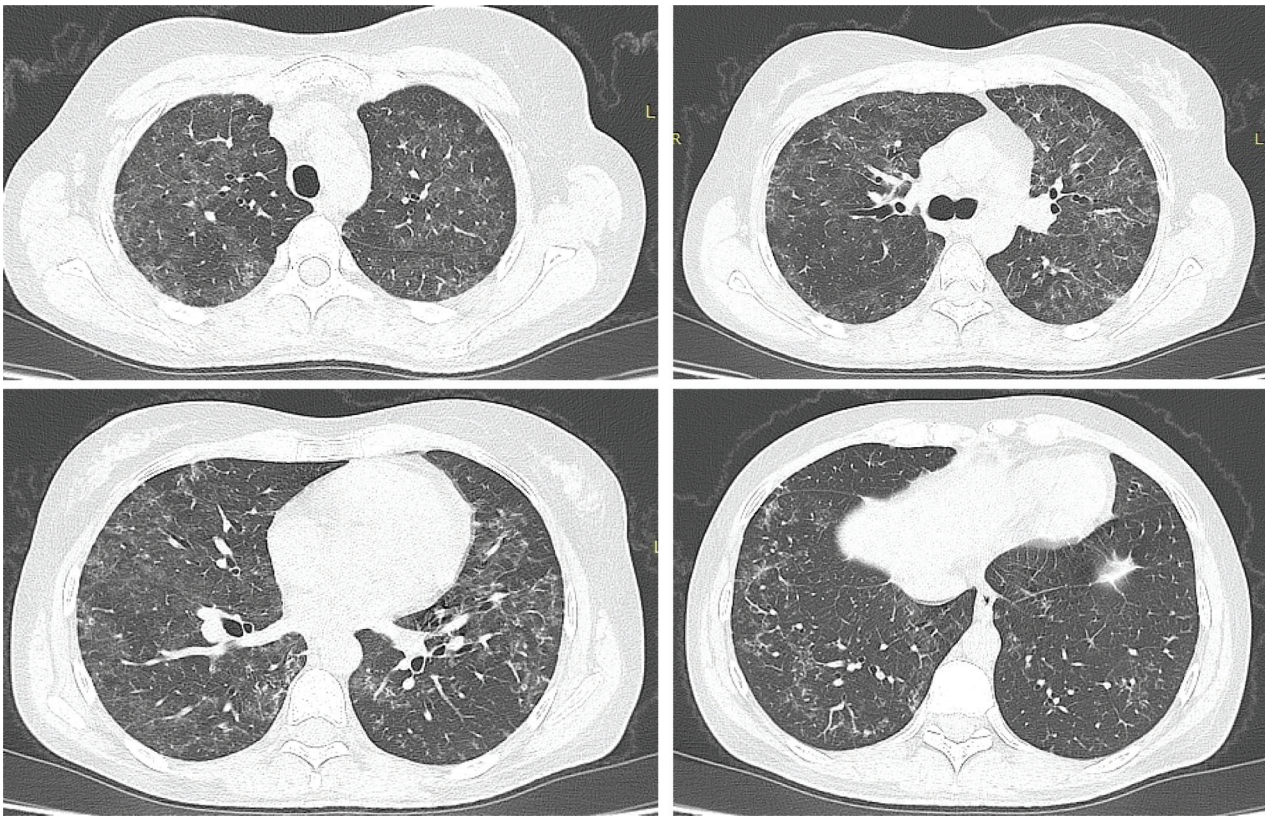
Chest CT scan showing ground glass infiltrates predominantly in the upper lobes.
